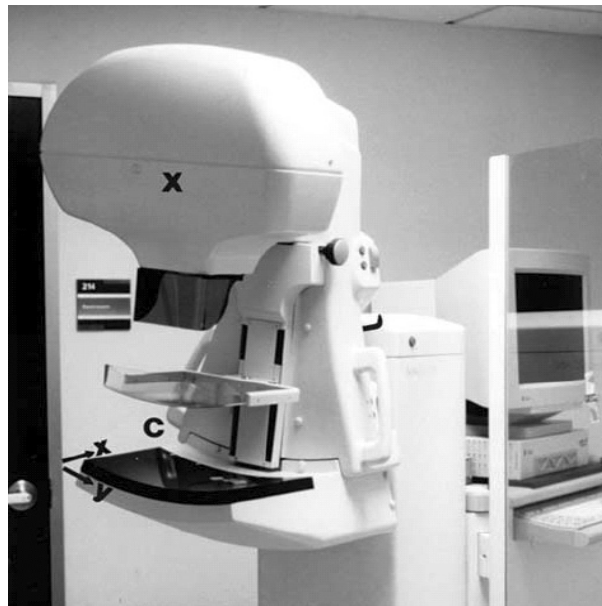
A slot-scanning digital mammography system. The slot with 300 pixel width covering the x-axis (4 400 pixels). The X-ray beam sweeps (arrow) in the y-direction producing over 5 500 pixels. X: X-ray and collimator housing, C: breast compressor.
